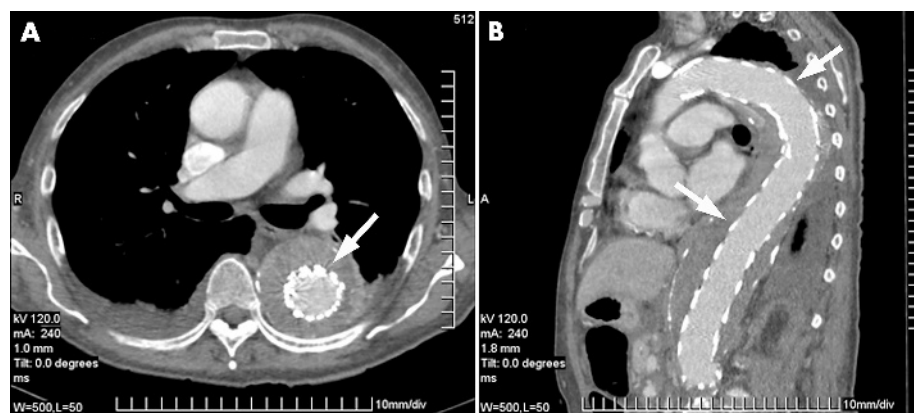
(A) Axial and (B) parasagittal CT images of an endovascular stent graft repair (arrows) of the descending thoracic aneurysm shown in figure 2D.
